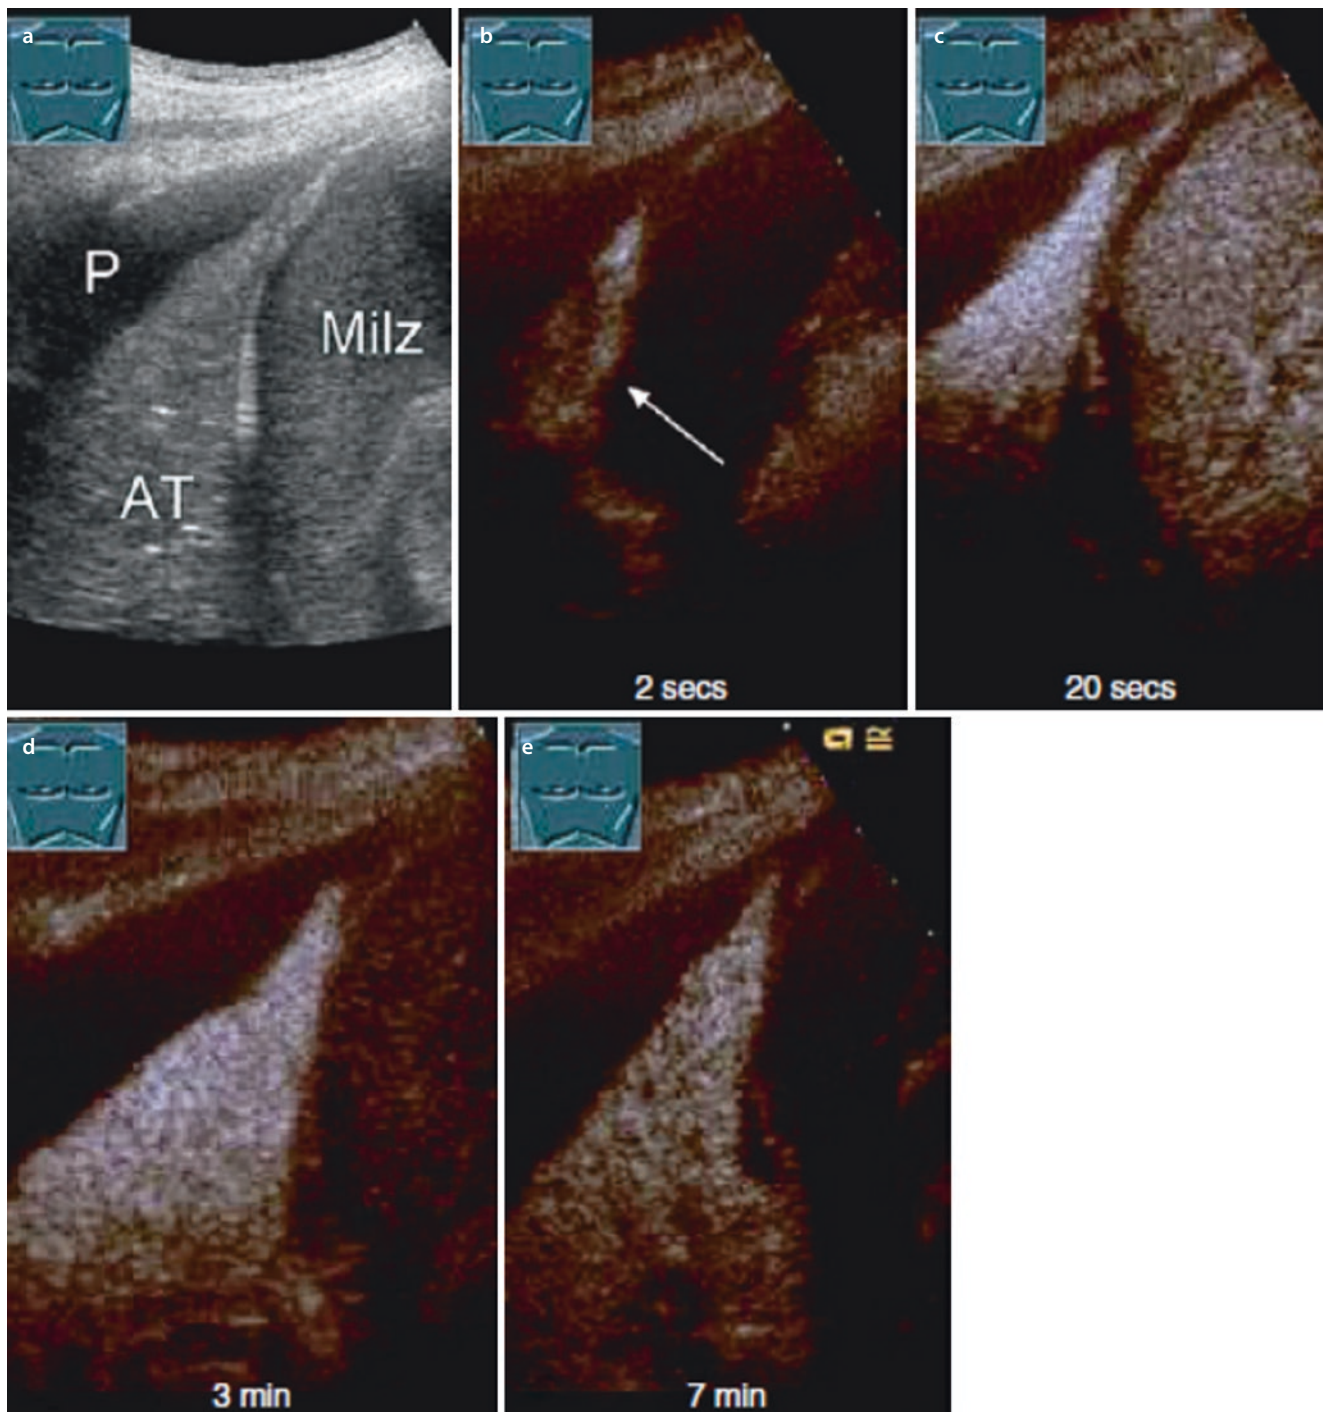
A 24-year-old man with a pleural effusion and compressive atelectasis in the presence of amyloidosis. a On the B-mode image one finds a pleural effusion (*P*), an atelectasis (*AT*) and in subcostal location the spleen. Contrast-assisted sonography shows early arterial contrast enhancement after 2 s (b). The *arrow* marks the vessel with starting contrast enhancement. After 20 s there is marked
